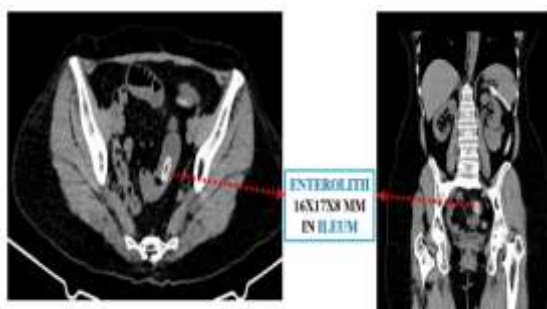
CT Abdomen after 48 hours of conservative management - Axial and Coronal views showing the presence of Enterolith in ileum, with no change in size or position
